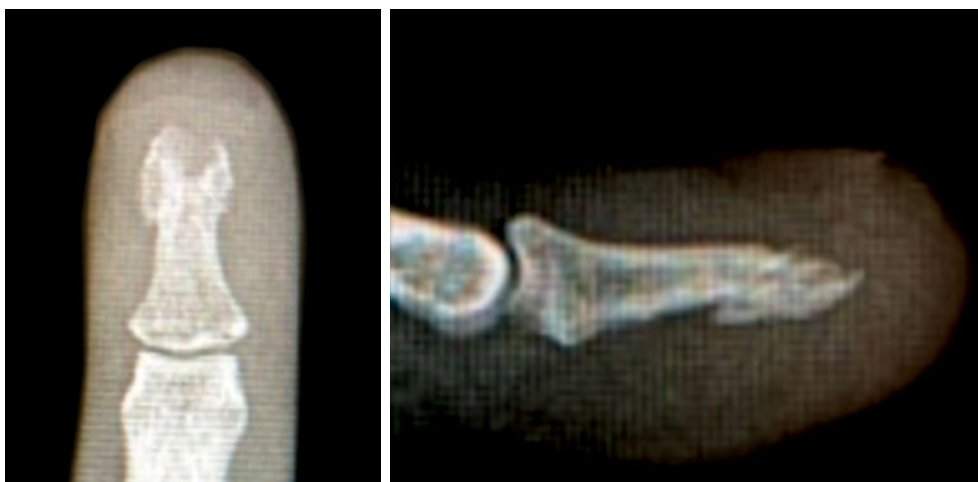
Anteroposterior and lateral radiographs showing local osteolysis due to osteomyelitis of distal phalanx.
